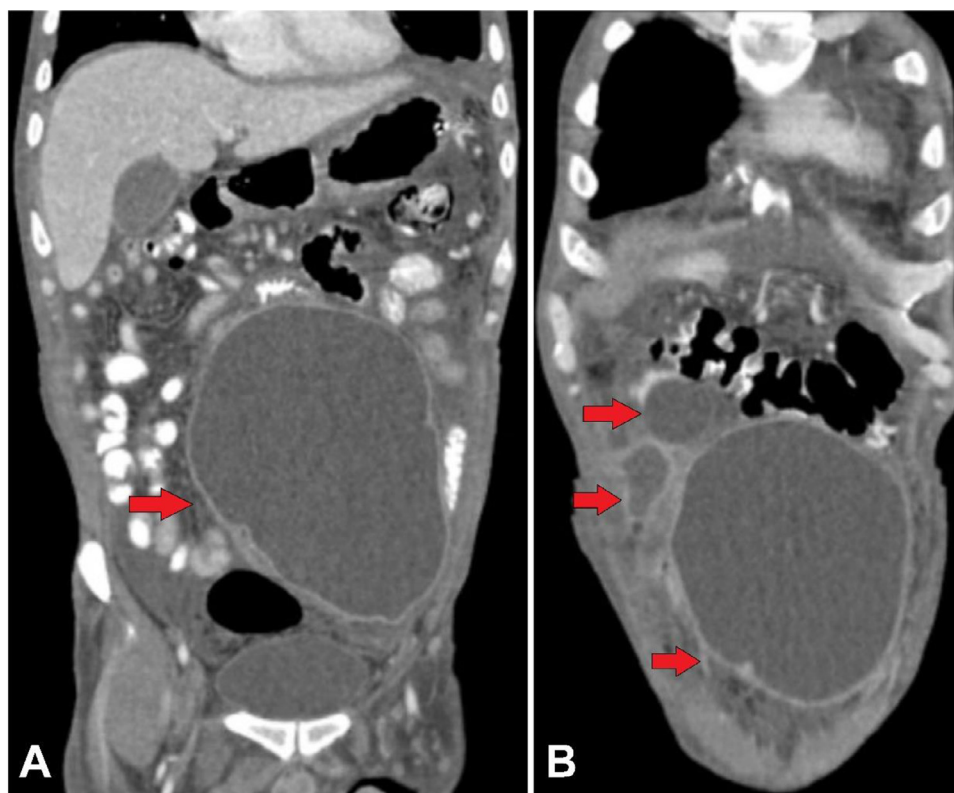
Computed tomography venous phase coronal sections (A) and (B) showing multiple well-defined peripherally enhancing cystic intra-peritoneal lesions (orange arrows) suggesting intra-peritoneal pseudocysts.
